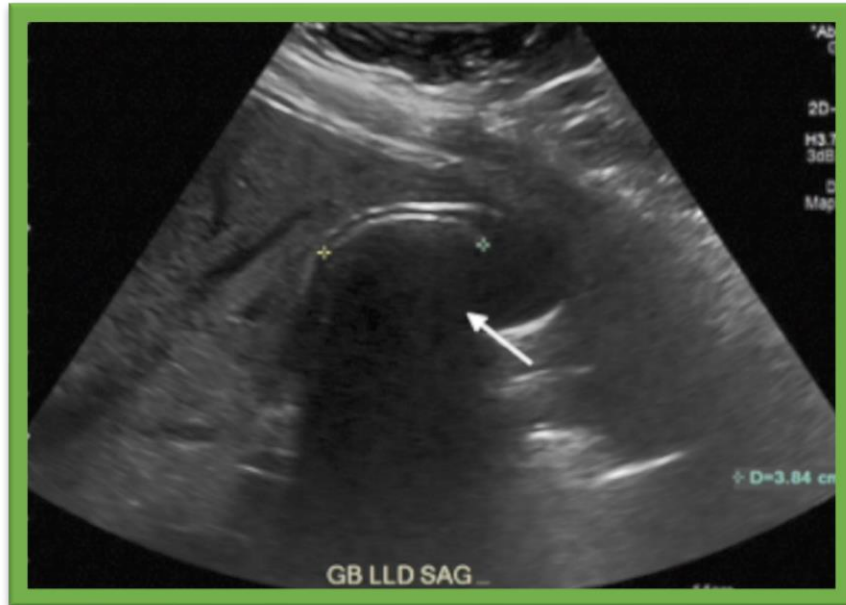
Right upper quadrant ultrasound revealing a 3.8cm gallstone
